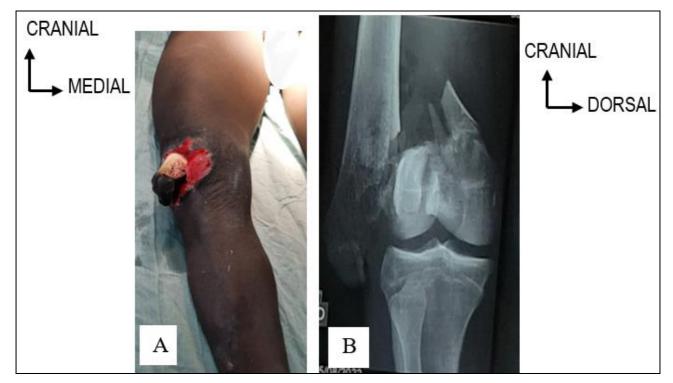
Neglected open supracondylar and intercondylar fracture of the right femur. A: Clinical aspect; B: Profile X-ray of the knee
